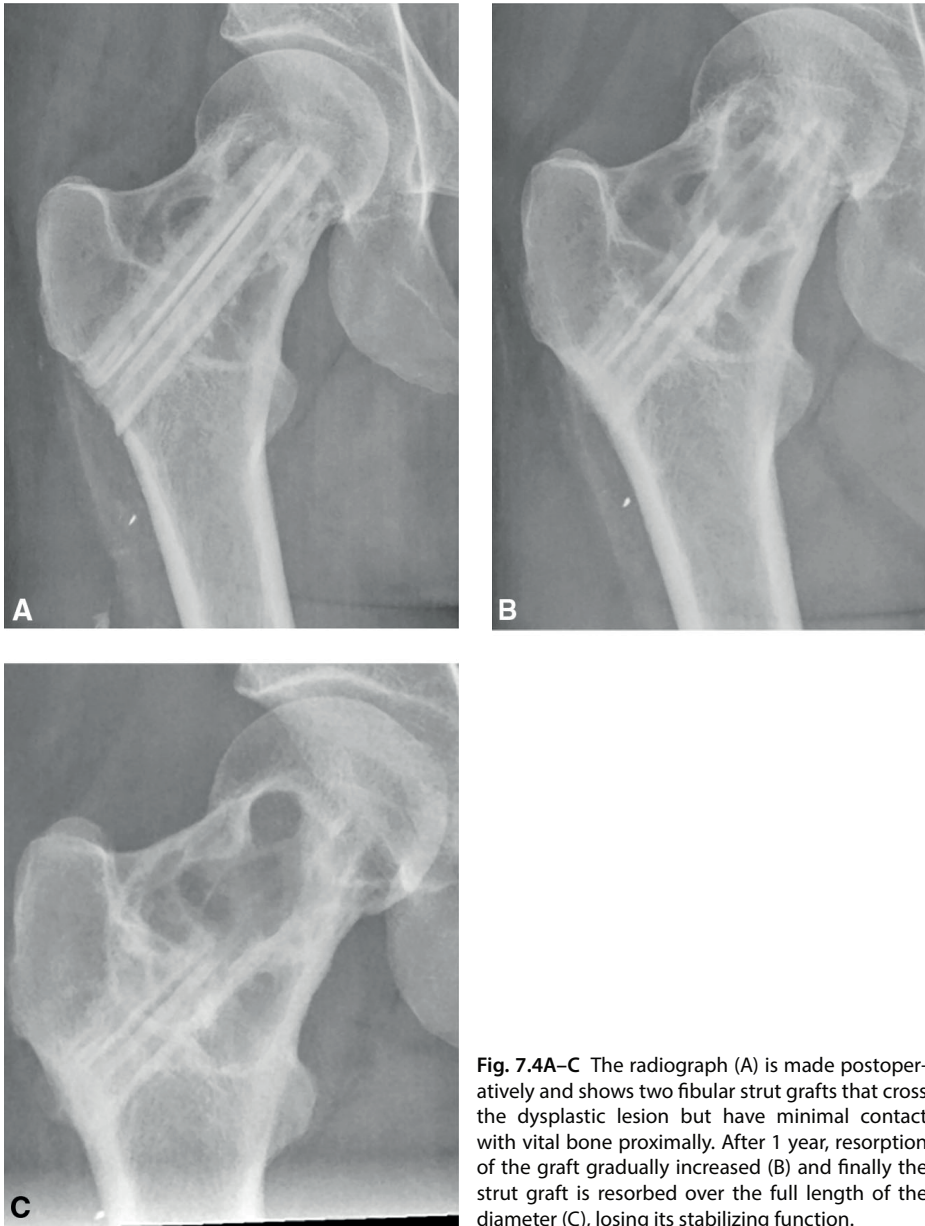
The radiograph (A) is made postoperatively and shows two fibular strut grafts that cross the dysplastic lesion but have minimal contact with vital bone proximally. After 1 year, resorption of the graft gradually increased (B) and finally the strut graft is resorbed over the full length of the diameter (C), losing its stabilizing function.
